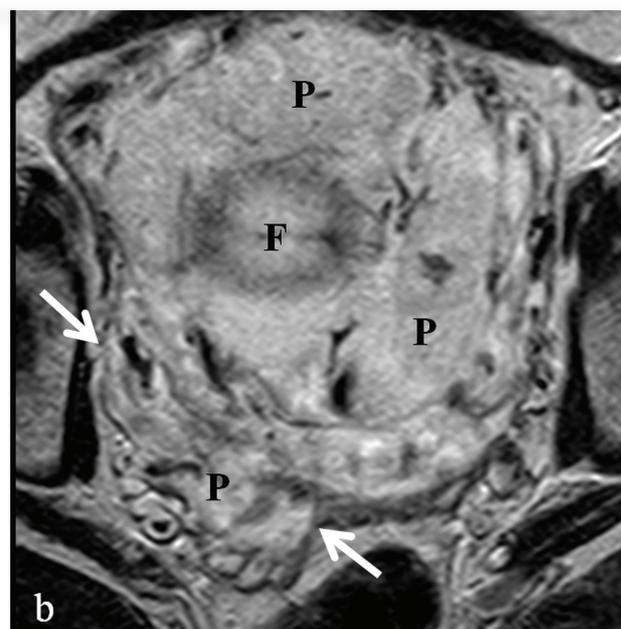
(a) Sagittal T2-W MR image of a 36-year-old patient with invasive placenta at week 34 of gestation. Placental tissue (P) completely covers the internal cervical os (arrow)
